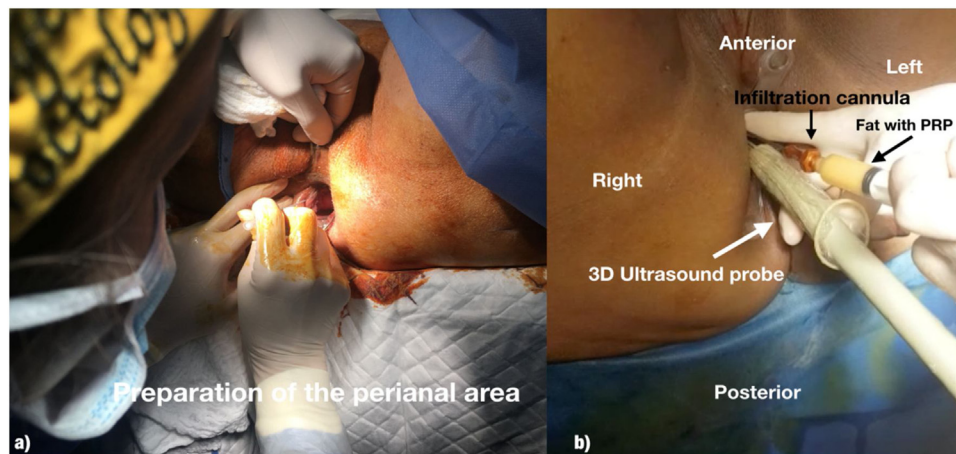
a) Preparation of the perianal area. b) Fat placement as appropriate (submucosal or intersphincteric space) under ultrasound vision.
